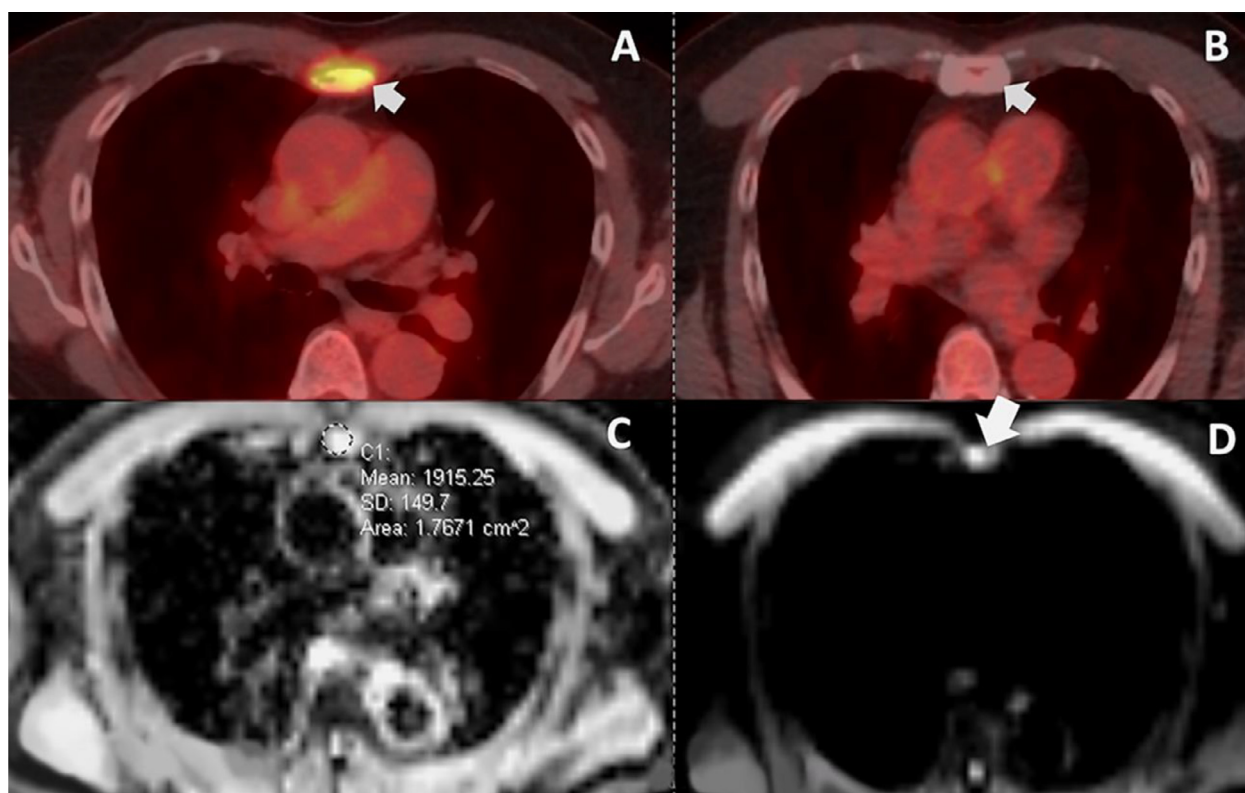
A 72-year-old man with multiple myeloma. (A) Fused axial pretreatment FDG PET/CT demonstrates an avid lesion in the sternum (small arrow). (B) Fused axial post-treatment FDG PET/CT demonstrates metabolic normalization (small arrow). (C) Axial post-treatment ADC map demonstrates a nonrestricting lesion displaying a mean ADC of $1.9 \times 10^{-3} \text{ mm}^2/\text{s}$ (circular region of interest (ROI)), that is consistent with granulation tissue and positive therapeutic response. (D) Axial post-treatment DWI displays a hyperintense lesion (large arrow) without corresponding ADC restriction (as demonstrated in C). The PET/CT and DWI/ADC findings are indicative of an interval positive treatment response.
